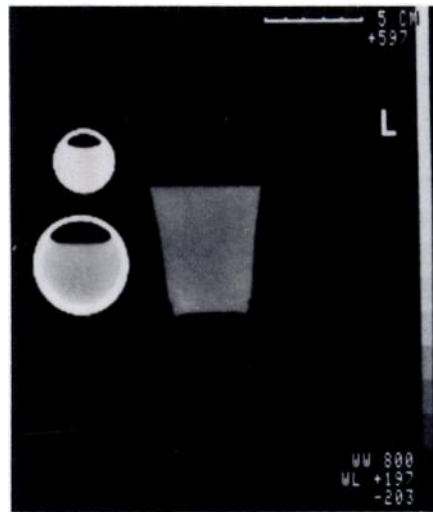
A 6-mm-thick CT section of three solutions: Gd-DTPA for intravenous use (upper left), Gd-DTPA for oral use (lower left), and tap water in a plastic cup (right). The two Gd-DTPA solutions were scanned in their original containers of glass.
